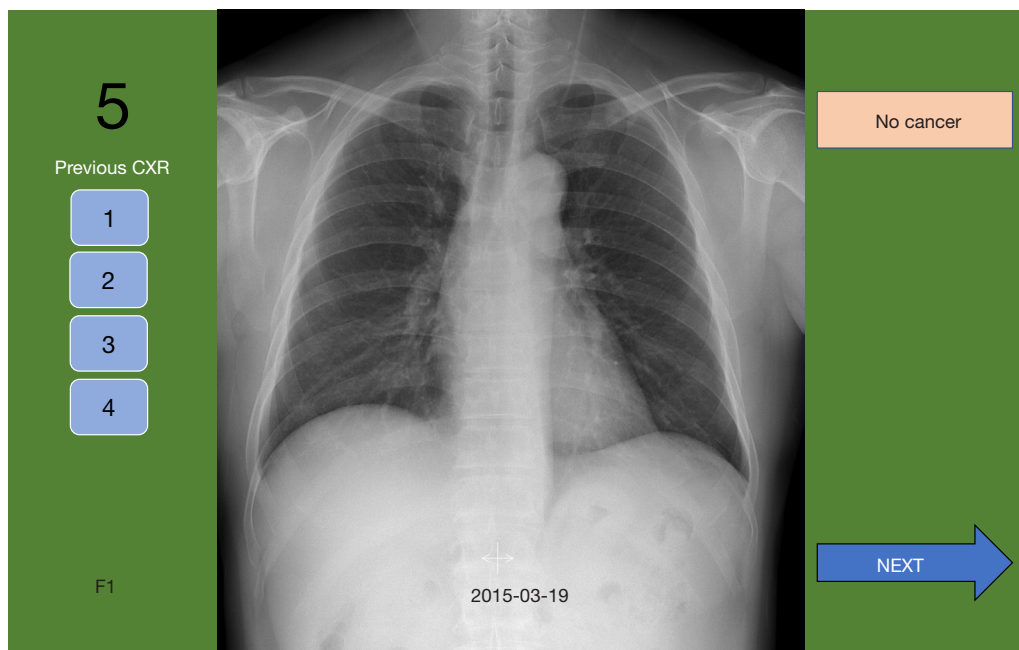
A sample screen of a CXR viewed by participants. CXR, chest radiography.
